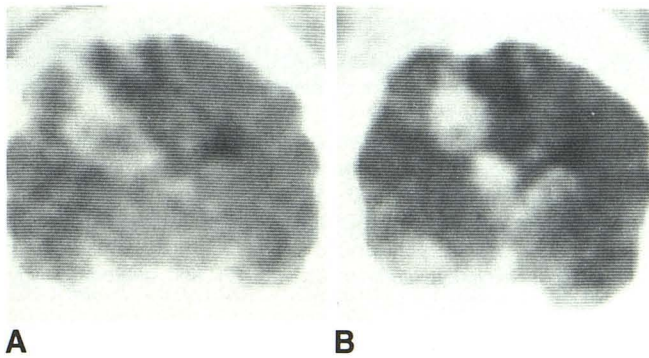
Postcontrast CT scans (10 min postinfusion) of an abscess on day 7 (A) and day 14 (B) after inoculation. Ring enhancement, as well as “pointing” of the abscess toward the ventricular system, were evident in the late cerebritis stage (A). In the early capsule stage, ventricular rupture was present with marked enhancement in both lateral ventricles and the right temporal horn (B). The parenchymal lesion was smaller than on day 7.
